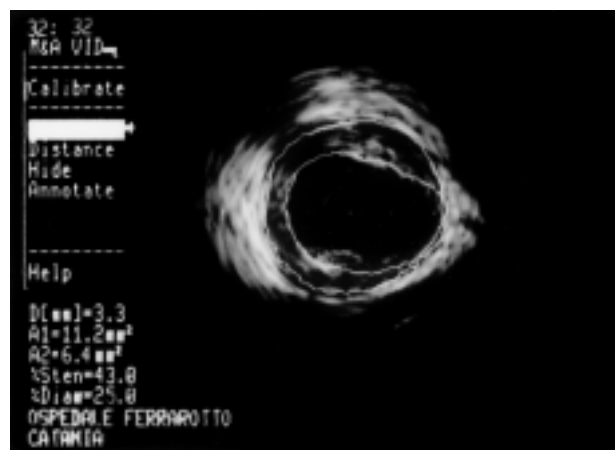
Intracoronary ultrasound examination at the site of the maximal mid left anterior descending coronary artery stenosis.
